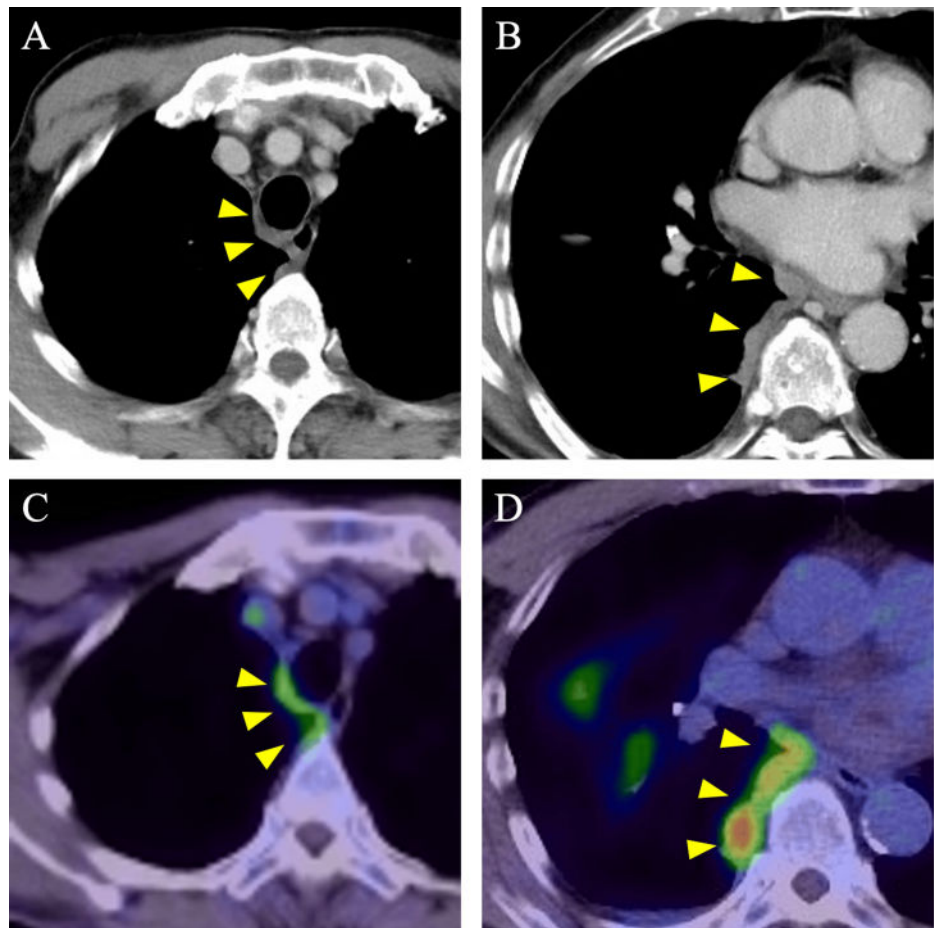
Chest computed tomography (CT) and positron emission tomography-computed tomography (PET-CT) findings at diagnosis.
